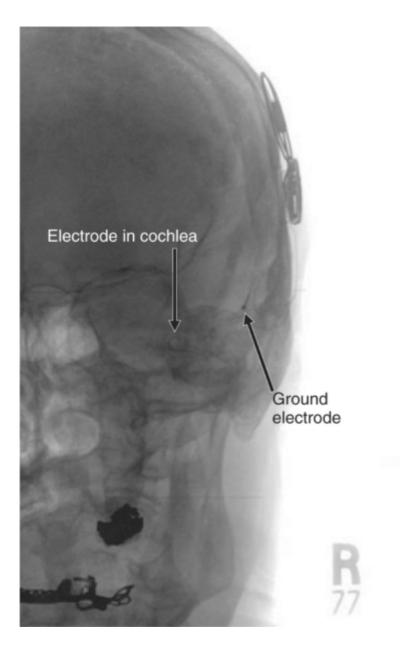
Anteroposterior radiograph of the skull showing good electrode placement within the cochlea.
